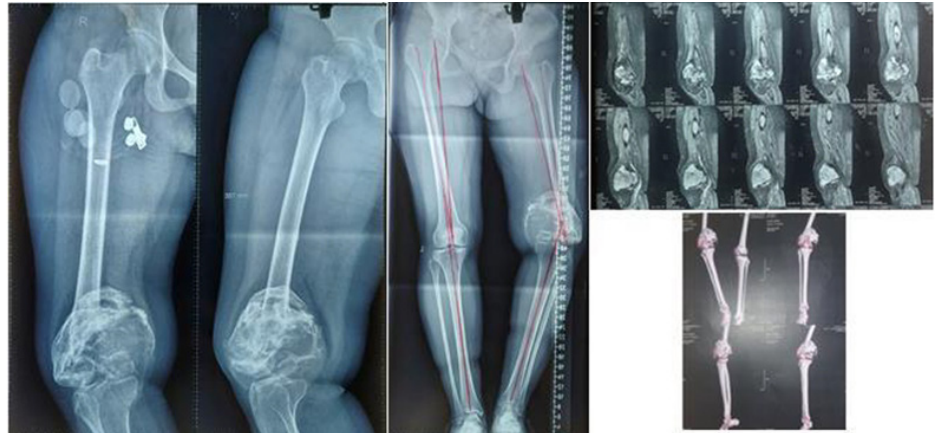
AP/Lat and full inferior extremity X-ray. MRI contrast and CT- scan 3D of the patient's right knee.
